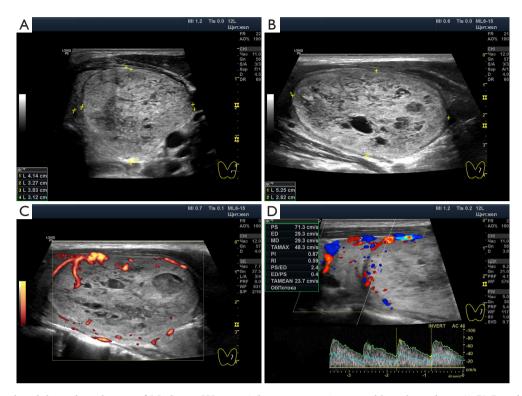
Thyroid nodule at the substage of Moderate Wasting. The patient is 47 years old, euthyroidism. (A,B) Isoechoic and slightly hypoechoic tissue of a large nodule is determined. It also contains a single small anechoic (fluid) area, an almost moderate number of small hypoechoic elements in the lobules, and single significantly hypoechoic medium-sized segments. (C) Power Doppler mode detects little active blood flow in the nodule. (D) The artery approaching the nodule has a peak systolic velocity of 71 cm/s.
